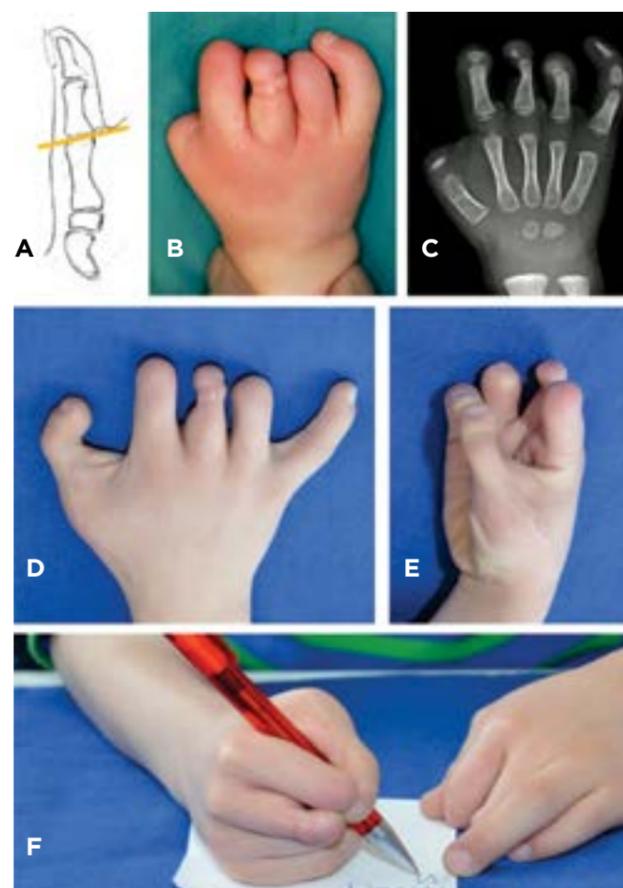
A: Thumb amputations at the MCP level may be suitable for toe to hand transfers. B, C: Preoperative X-ray and photograph. D, E, F: Postoperative result: At 3 yrs. of age, a toe-to-hand transfer with the second toe was performed. The boy had a very functional thumb with a powerful pinch at the 5-year follow-up. He remained right handed, despite having a normal thumb on the other hand (courtesy Wiebke Hulsemann, Children's Hospital Wilhelmstift, Hamburg).
